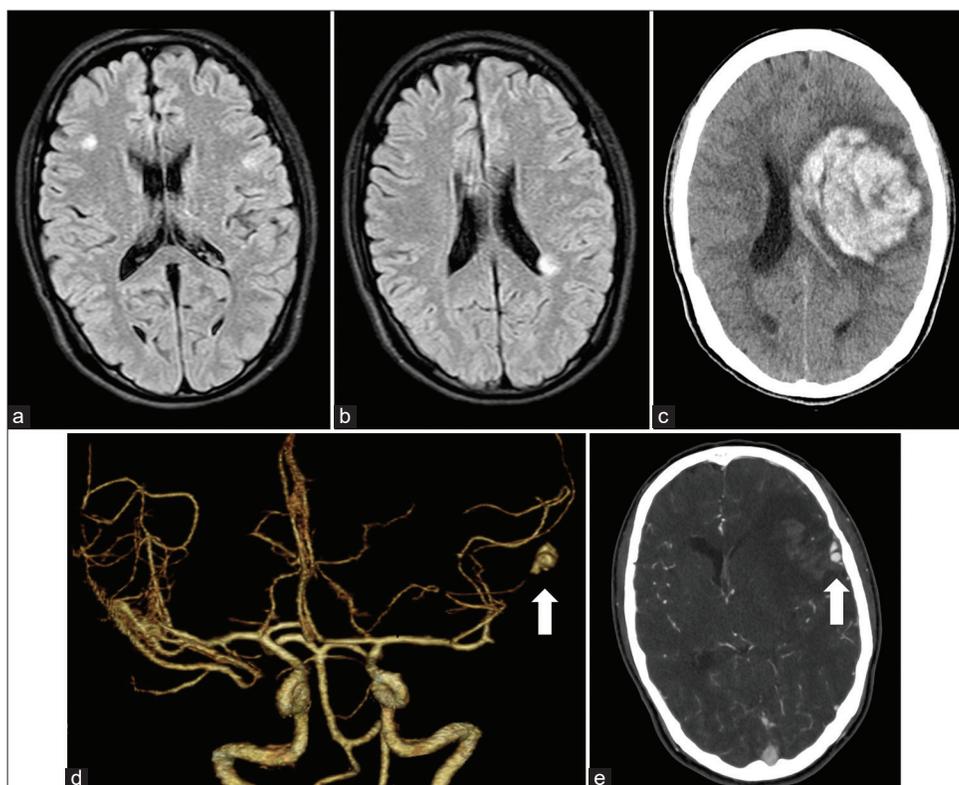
(a and b) Magnetic resonance imaging revealing acute cerebral infarction in the right frontal lobe near the left lateral ventricle. (c) Computed tomography revealed an intracerebral hemorrhage in the left frontal lobe. (d) A three-dimensional computed tomography angiography image showing an aneurysm in the distal middle cerebral artery (white arrow). (e) Axial computed tomography reveals bleeding from the aneurysm (white arrow).
